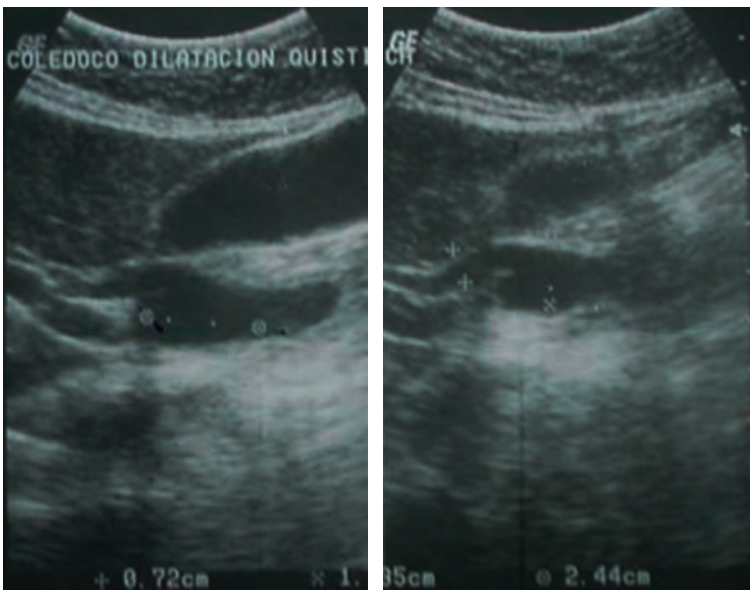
Liver and biliary tract ultrasonography study, with report of common bile duct cyst with microliths inside.
